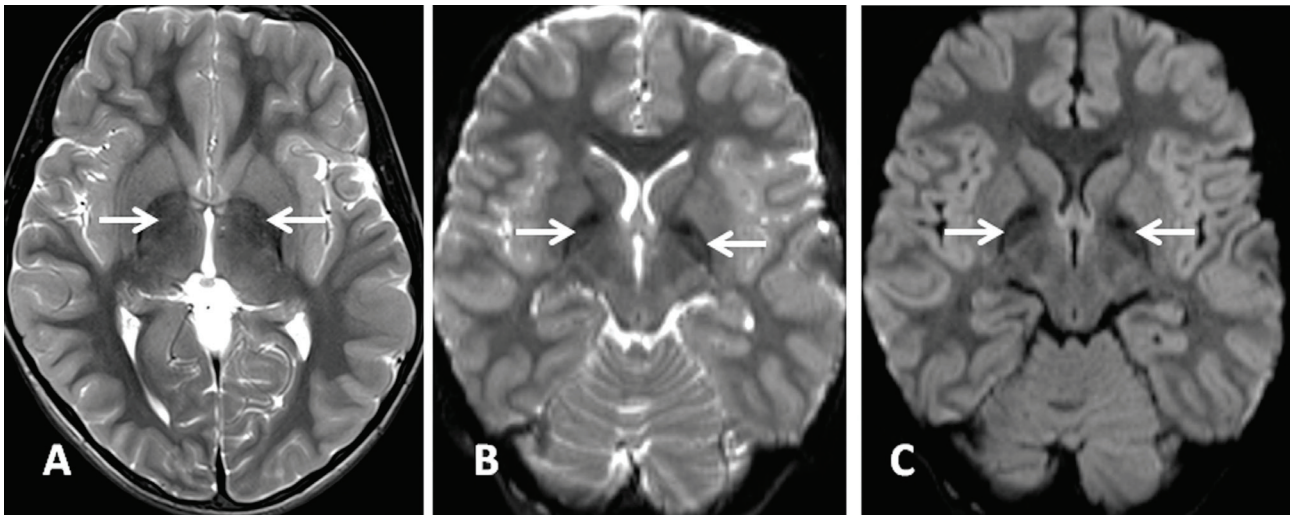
MRI brain axial T2-weighted sequence (A), axial diffusion sequence b value 0 s/mm² (B) and axial diffusion sequence b value 1000 s/mm² (C) showing low/dark signal intensity of bilateral globus pallidus suggestive of excessive iron accumulation (arrows).
